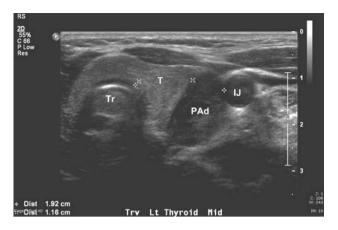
Corresponding cervical ultrasound from the patient shown in Fig. 1, showing a large hypoechoic cystic parathyroid adenoma (PAd). The left thyroid (T), trachea (Tr), and left internal jugular vein (IJ) are indicated
